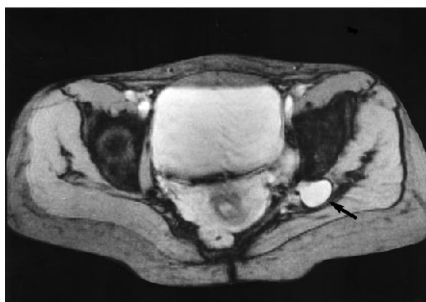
A, Axial T1-weighted image (540/10/2 [repetition time/echo time/excitations], 240×256 matrix) shows a hyperintense lesion (arrow) in the left sciatic notch, partially surrounded by a thin hypointense zone (which represents granular tissue composed of macrophages filled with hemosiderin and determined on pathologic analysis). PM indicates piriformis muscle; GM, gluteus maximus muscle; Gm, gluteus medius muscle; gm, gluteus minimus muscle; IP, ilio-psoas muscle; and IS, ischial spine.
